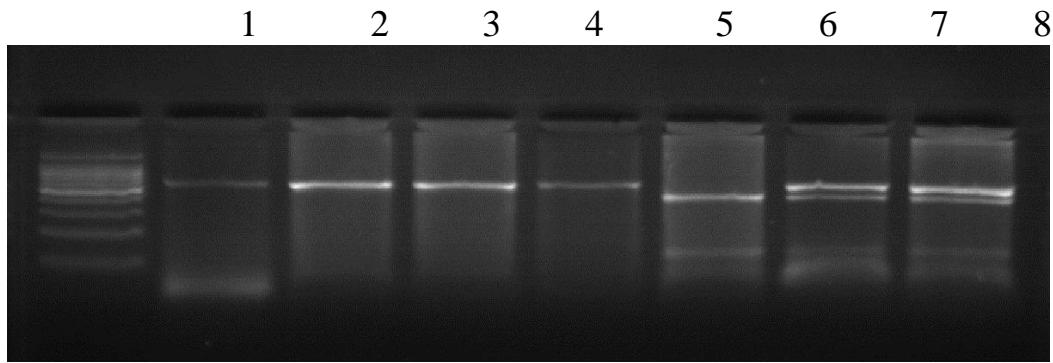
(3.6) The PCR-based restriction analysis of the DIO1a-C/T shown on 2% agarose electrophoresis. A PCR fragment was generated of 565 bp. The BclI restriction enzyme cuts in the C/T region generates two fragments of 434 and 131 bp only in the presence of the D1a-T allele (polymorphic homozygote) genotype; in the presence of the 565- and 434-bp, the fragments were shown to be CT (polymorphic heterozygote) genotype. Lane 1 was loaded with 50 bp ladder ; lane 2 is PCR product 565 bp; lanes 3, 4 and 5 are homozygous CC subjects; lanes 6 is homozygous TT subjects; lanes 7 and 8 are heterozygous CT subjects.
